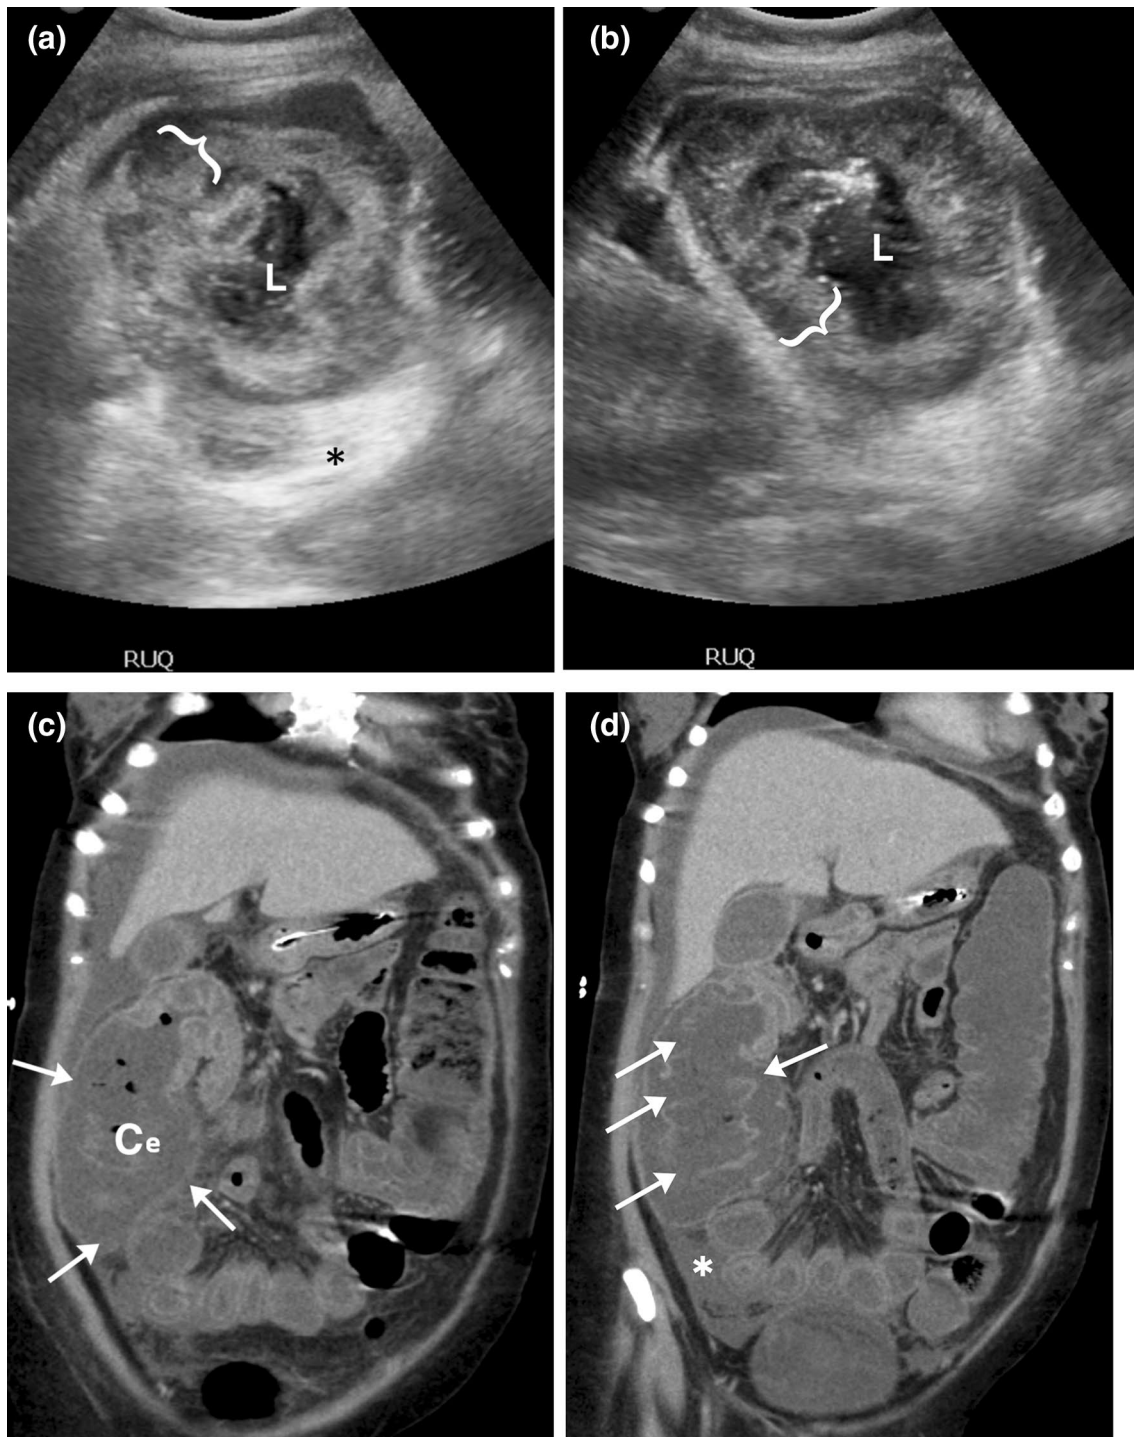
Typhlitis in a 30-year-old female with history of relapsed AML presented to the emergency department with severe abdominal pain. a Gray scale transverse and B longitudinal ultrasound images demonstrate markedly thickened heterogeneous echogenicity cecal wall (brackets). The lumen of the cecum is dilated and contains complex debris and air (L). Note marked echogenicity of the inflamed
